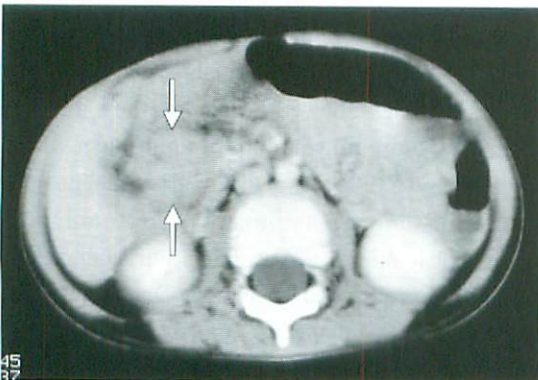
Contrast-enhanced computed tomography of the abdomen on 2nd day showed a low-attenuation demarcated oval-shaped mass along the inferior vena cava and around the duodenum.
